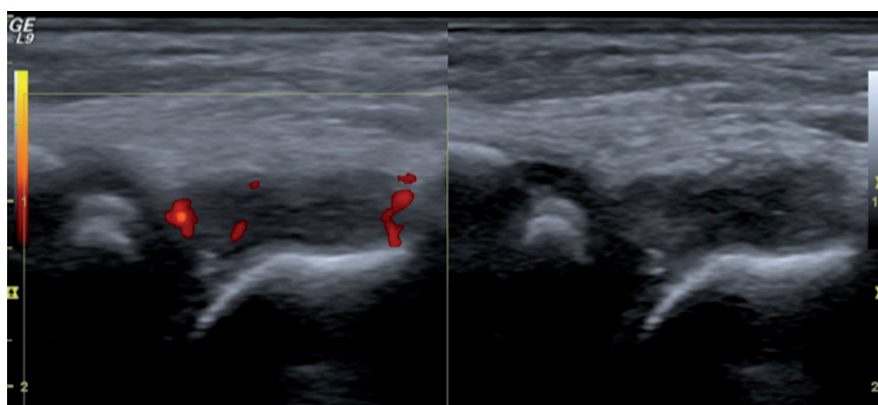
Scoring system used for assessment of power Doppler (PD) synovitis. Binary scoring system for PD-synovitis in JIA showed in a longitudinal sonogram of the tibio-talar joint.
